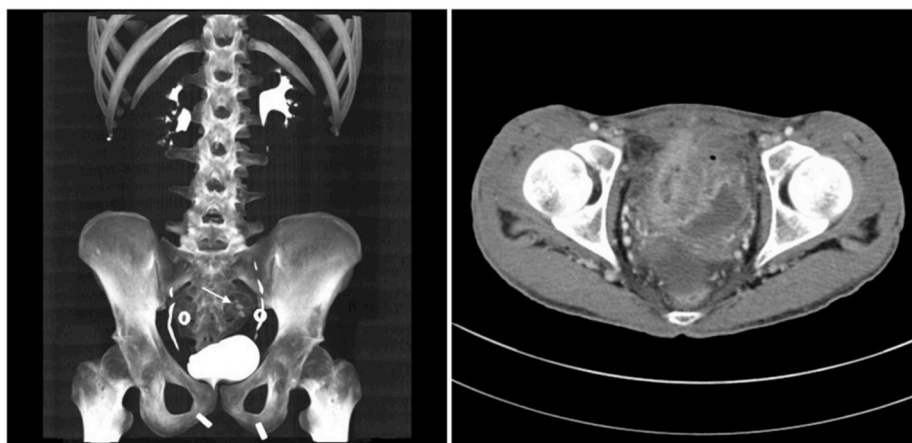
Computed Tomography images of a mass involving the bladder and small intestine. with contrast passing into the small intestine.
